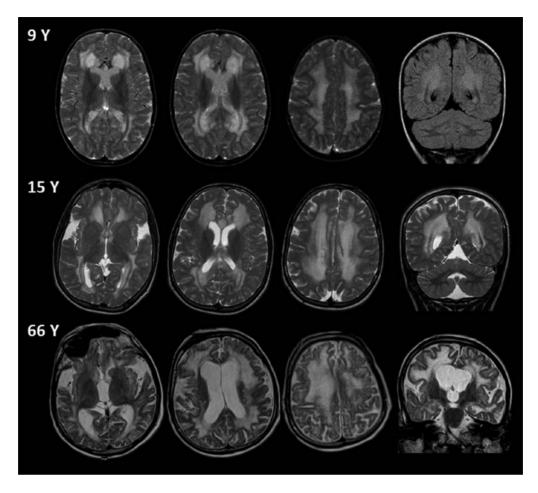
Cranial MRI studies in patients with presumed late-onset type glutaric aciduria type I at different ages. Patients were asymptomatic during infancy and early childhood. T₂-weighted MRI scans showed confluent supratentorial hyperintensities of white matter spreading from the periventricular zone to the U-fibers. Basal ganglia remained unaffected. Dilation of extracerebral CSF spaces and ventricles were variable. "Leukodystrophy" was suspected (With courtesy of Drs Inga Harting and Angelika Seitz, Department of Neuroradiology, University Hospital Heidelberg, Germany).
